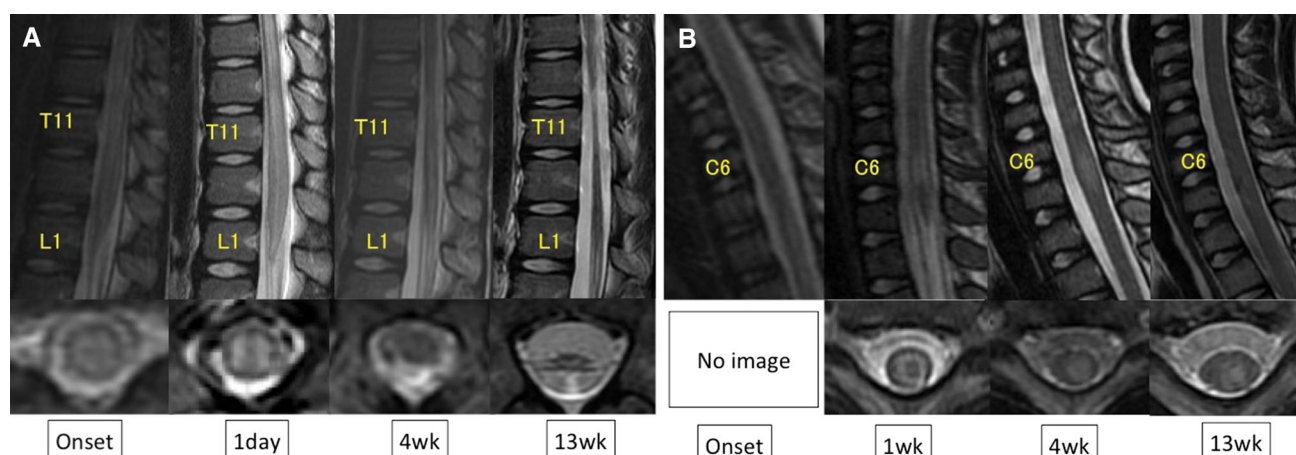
Consecutive T2-weighted magnetic resonance images of lumbar and cervical spine. a Lumbar spine sagittal images and axial images at T11 vertebral level. b Cervical spine sagittal images and axial images at C6 vertebral level
